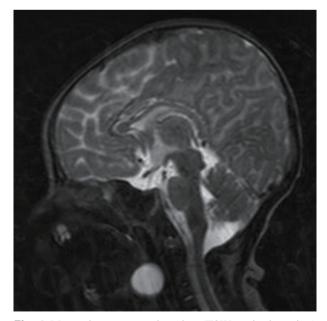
Magnetic resonance imaging (T2W sagittal section) shows a 1.4×1.5 cm cyst in diameter (arrow) in the base of tongue.
